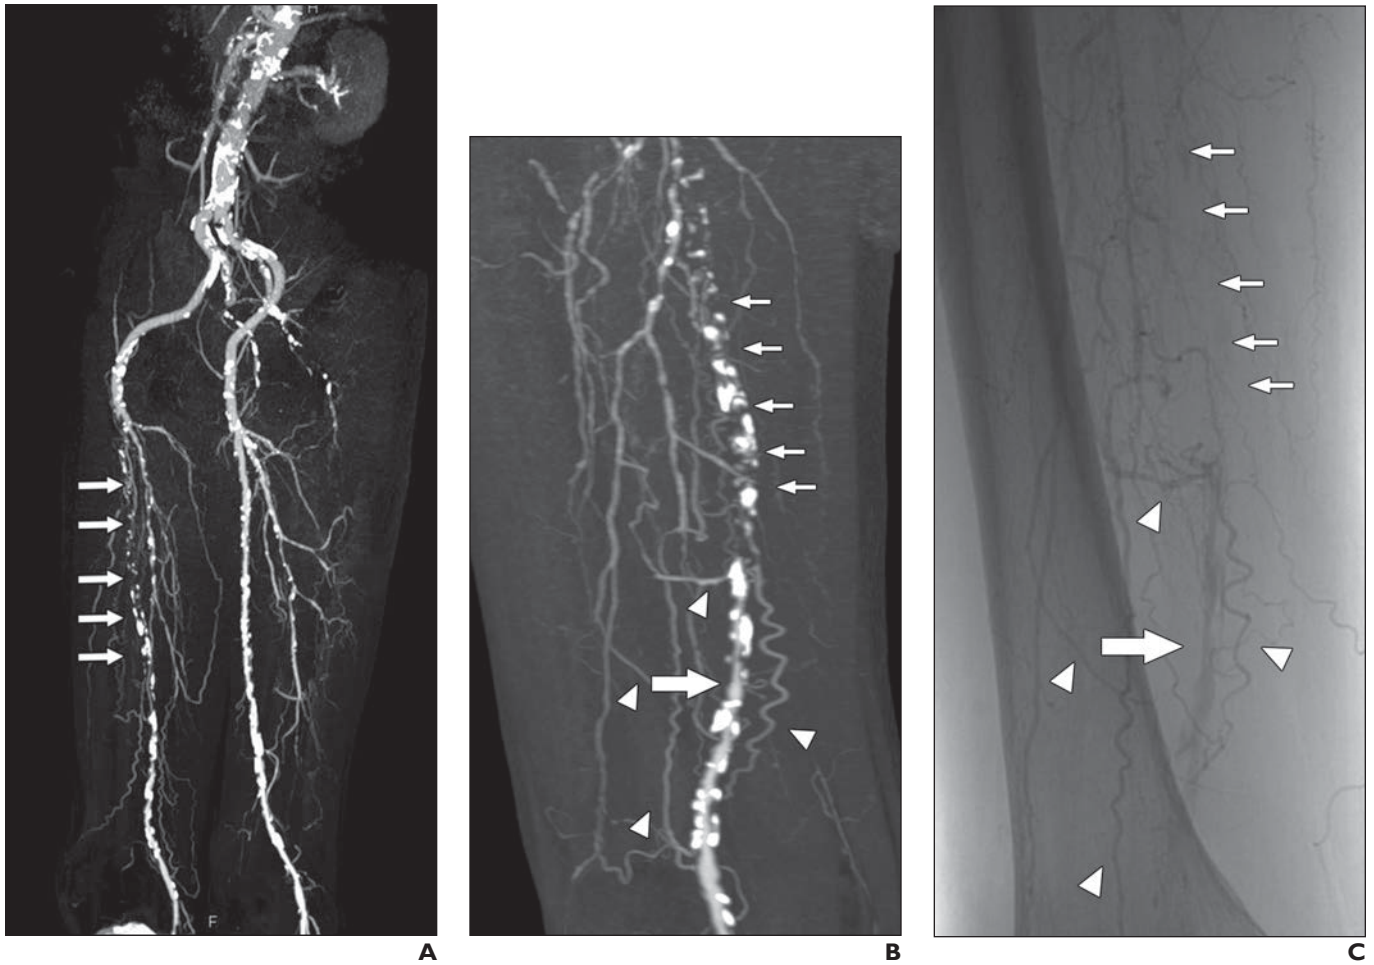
72-year-old man with peripheral arterial occlusive disease and intermittent claudication of right leg. Dual-source CT angiography was performed at 70 kV and 305 effective mAs/rotation (dose-length product, 466 mGy × cm).
